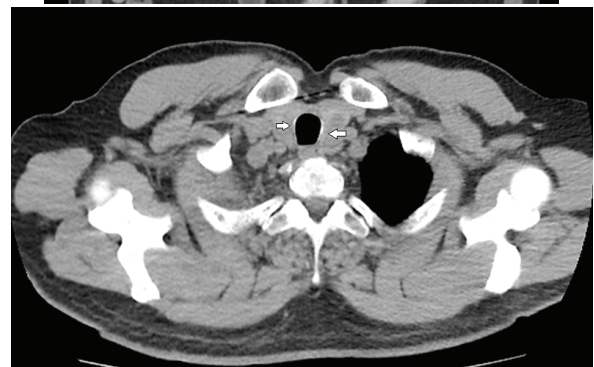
Chest computed tomography showed calcified lesions (arrows) on the tracheal wall.
